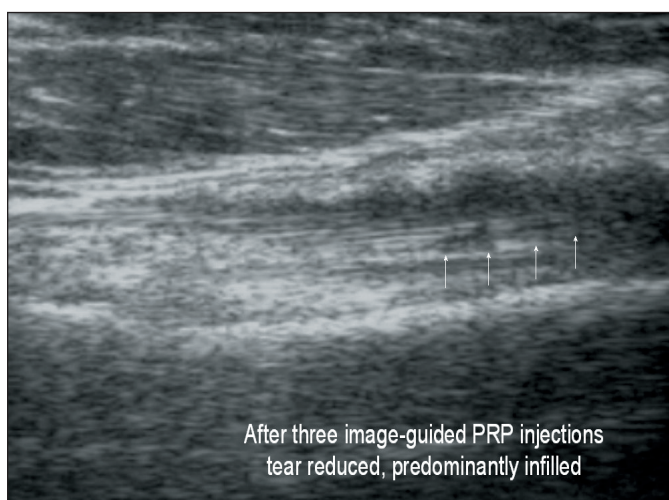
Resolved tear of long head biceps tendon post three ultrasound image-guided PRP injections.
